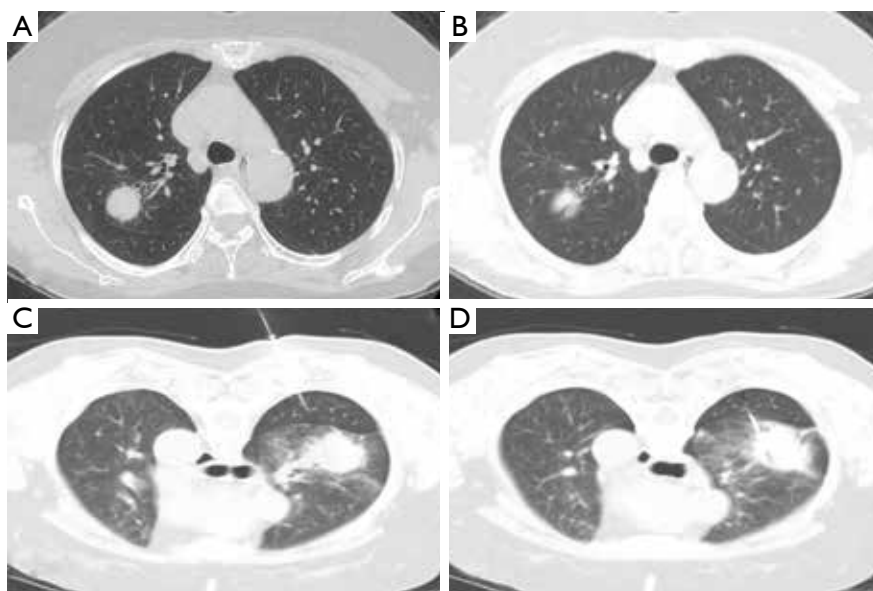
(A,B) Computed tomography (CT) of the chest showing that the primary lesion was located deeply and the scapula interfered with the anterior approach while performing percutaneous needle biopsy. However, there was no evidence of synchronous or metastatic nodules in the superior segment of the RLL; (C,D) CT-guided percutaneous needle biopsy (CT-PNB) of the primary lesion: the biopsy needle passed through the superior segment of the right lower lobe to target the right upper lobe mass.
